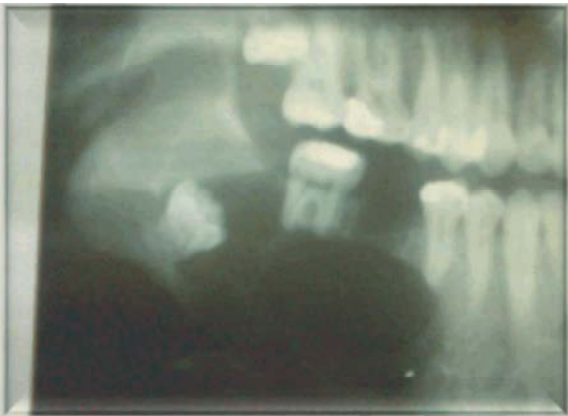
Panoramic radiograph showing immediate postoperative after extraction of the first molar for depressurizing of the dentigerous cystic cavity.
